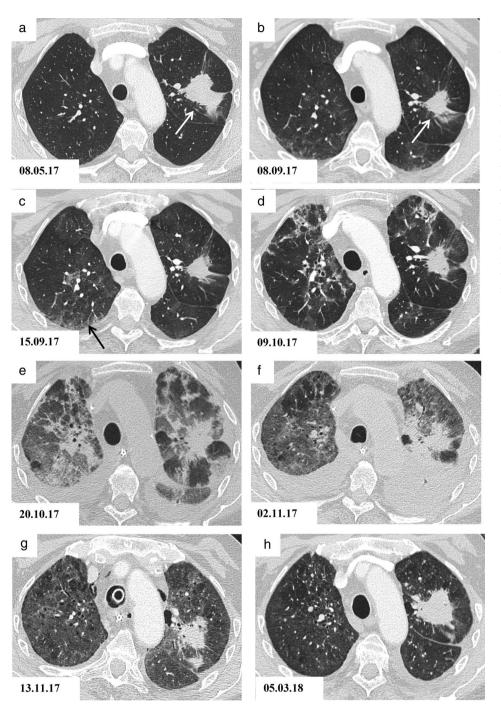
High-resolution computed tomography (HRCT) scan of the thorax showing subsequent pulmonary changes. (a) Before osimertinib treatment; (b) after four months of osimertinib treatment, no clinical symptoms; (c) ongoing treatment with osimertinib, onset of dyspnea; (d) osimertinib treatment was stopped due to severe hypoxia; (e) no osimertinib, mechanical ventilation, high dose steroid treatment; (f) ongoing mechanical ventilation due to severe hypoxia, steroid treatment; (a) ongoing steroid treatment, with a slow improvement: and (h) no tumor treatment, tumor progression. White arrows mark the primary tumor, black arrows mark pulmonary infiltrates.
